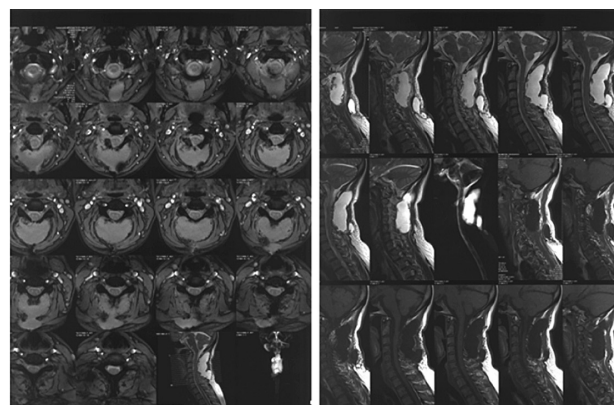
The first post operation cervical MRI two weeks after the surgery.
